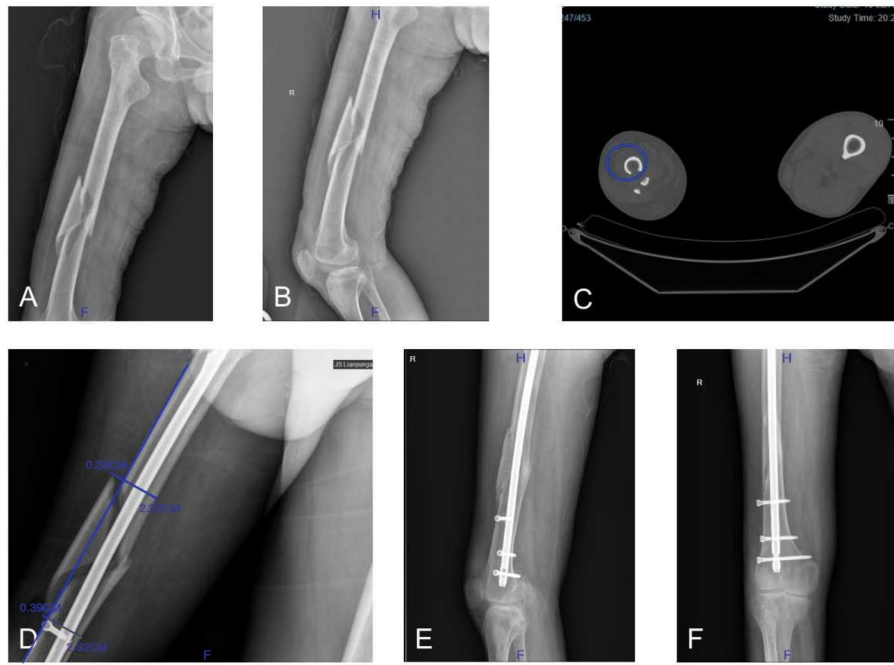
A 60-year-old male patient presented with a right femoral shaft fracture, classified as degree I displacement with type 3 circumference, caused by a fall on an electric car, which was treated with intramedullary nails 9 days after injury. (A, B) AP views in preoperative X-rays showed femoral shaft fracture with butterfly fracture fragments; (C) Preoperative CT tomography showed femoral shaft type 3 circumferential fracture; (D) Postoperative X-ray showed femoral shaft fracture with degree I displaced fragment; (E, F) AP views in postoperative radiographs 9 months after surgery showed fracture healing.
